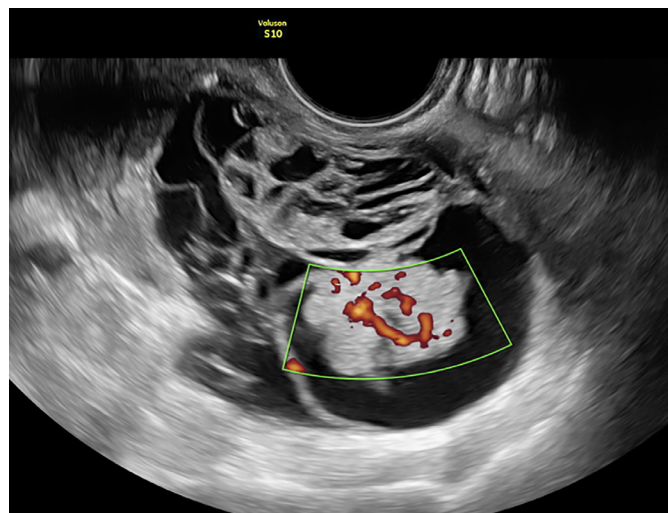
Ultrasonographic aspect of the endometrioid ovarian cancer in the context of ORS. It appears as a large, unilateral, multilocular-solid tumour, with anechoic cystic fluid. A large central solid component located within locules can be observed corresponding to a cockade-like sign.
